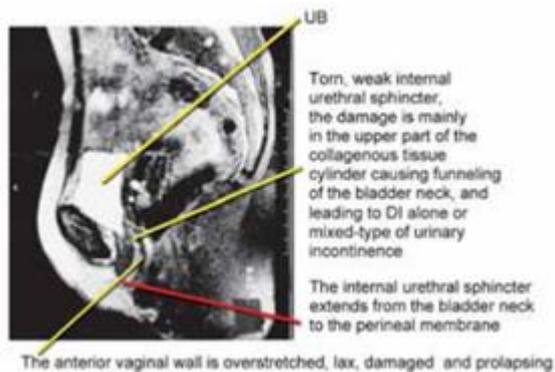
An image by MRI, sagittal section that clearly shows the IUS as a cylinder that extends from the bladder neck to the perineal membrane. The IUS is torn mainly in its upper part leading to funneling of the bladder neck. Note that the anterior vaginal wall is torn and prolapsing.
